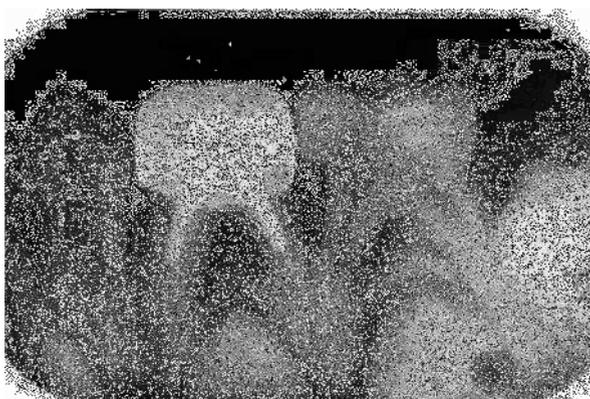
Two bitewing x-rays were performed the first time the child presented, 30.8.12
